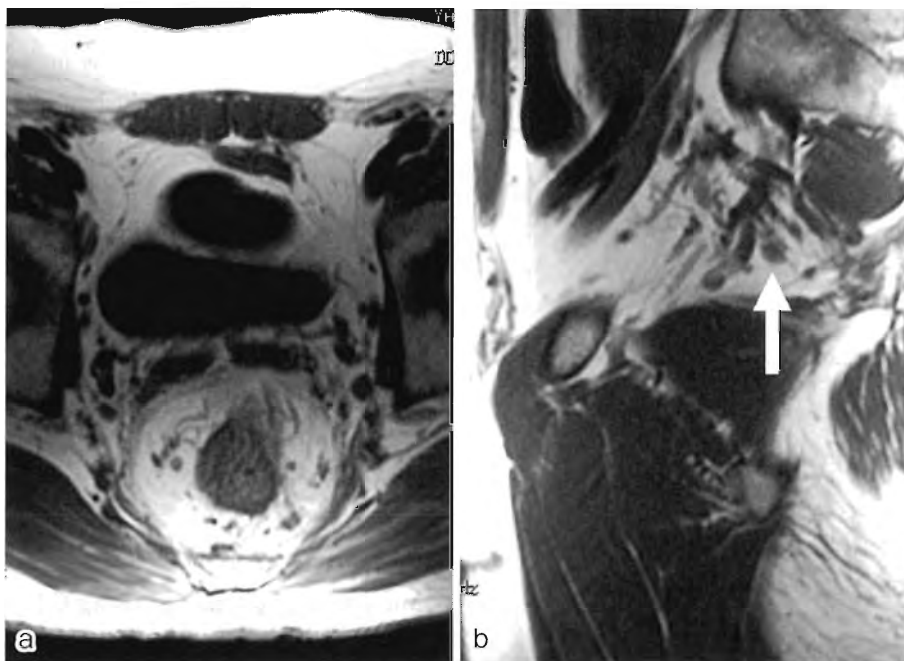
Diagnosis of lateral lymph node metastasis using MRI (T1WI)
